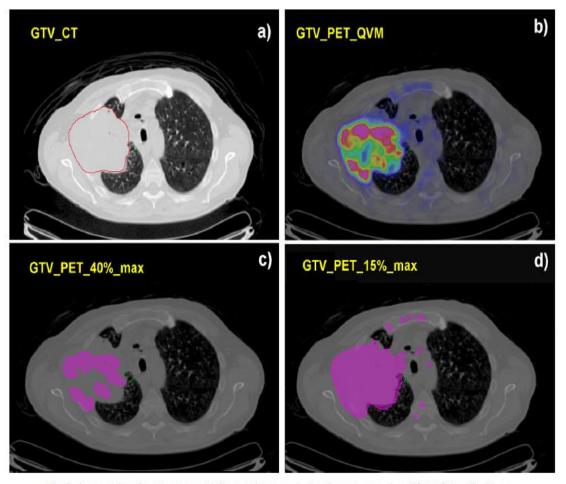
Segmentation of target volumes. (a) Computed tomography-based gross tumor volume (GTV_CT) outlined by radiation oncologist. (b) Positron emission tomography-based gross tumor volume (GTV_PET) outlined by same radiation oncologist. QVM = qualitative visual method. (c) Positron emission tomography-based volume, outlined using gross tumor volume 40% maximal uptake method (single maximum) (GTV_PET_40%_max). (d) Positron emission tomography-based volume, outlined using gross tumor volume 15% maximal uptake method (single maximum) (GTV_PET_15%_max).
